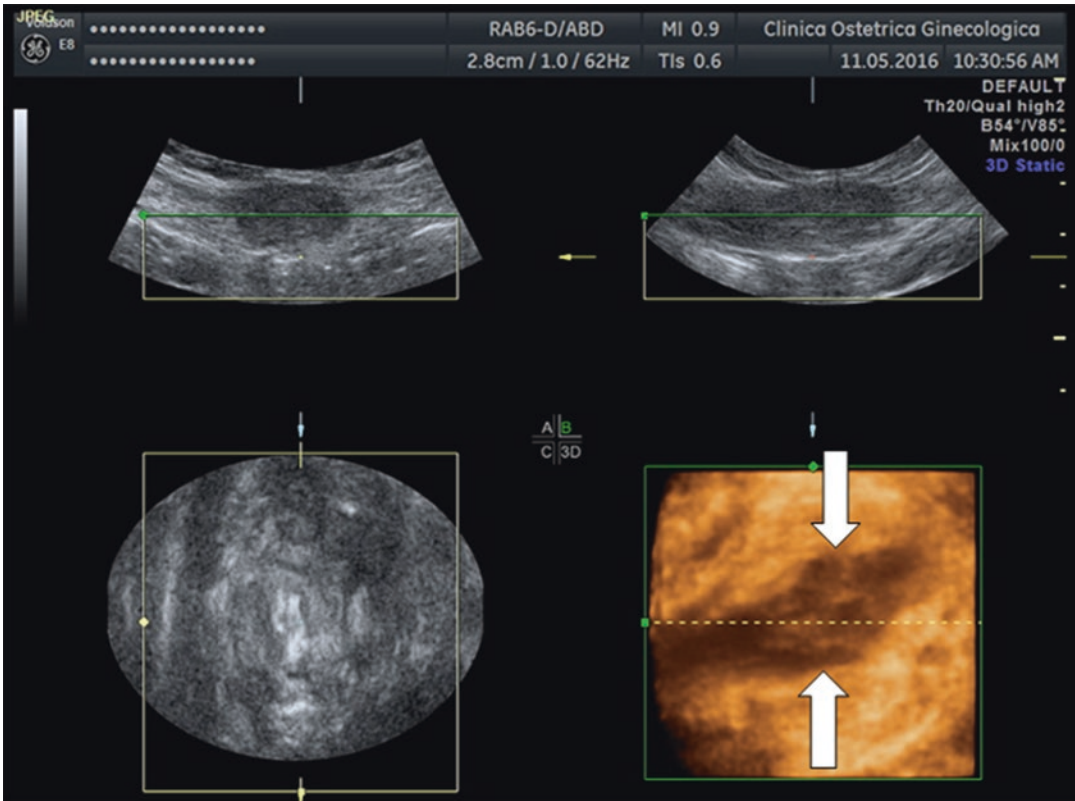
Three-dimensional ultrasonographic appearance of a *rectus abdominis endometriosis* (straight arrows) in a 30-year-old woman with one previous cesarean section 4 years before
